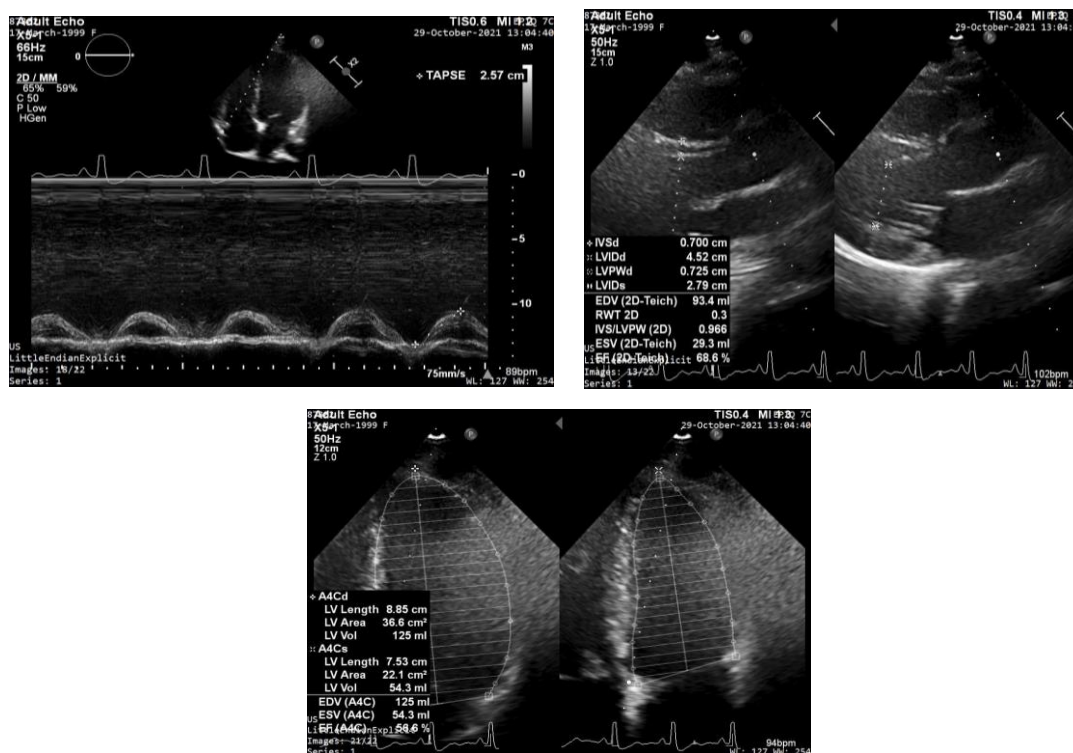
Echocardiography which was examined on 29th October 2021, showed normal cardiac dimension, good LV and RV function, normal diastolic function, and pulmonary and tricuspid regurgitation.
